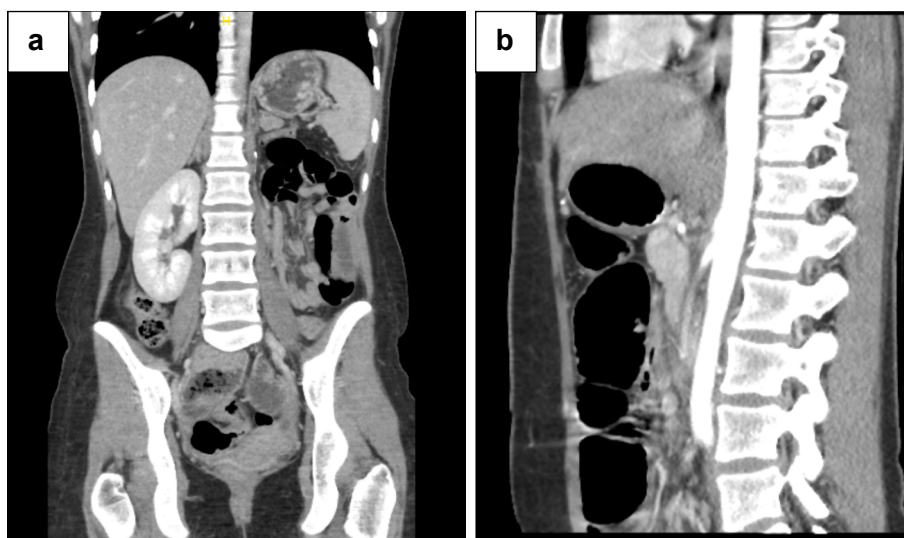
(a) Coronal and (b) sagittal abdominal CT with contrast 3 months postoperatively. The surgical bed is clear with no signs of recurrence or metastasis.
